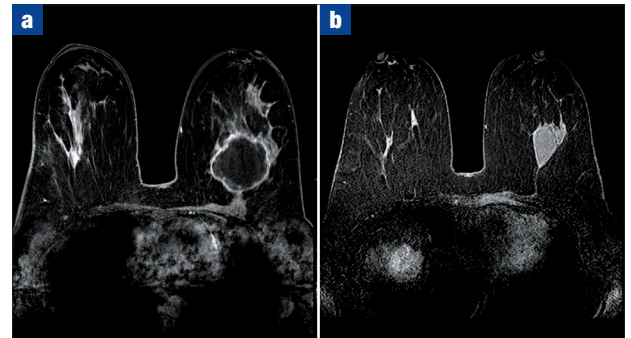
a. Pre-neoadjuvant chemotherapy magnetic resonance imaging and (b) post-neoadjuvant chemotherapy magnetic resonance imaging showing reduction in tumour size.
